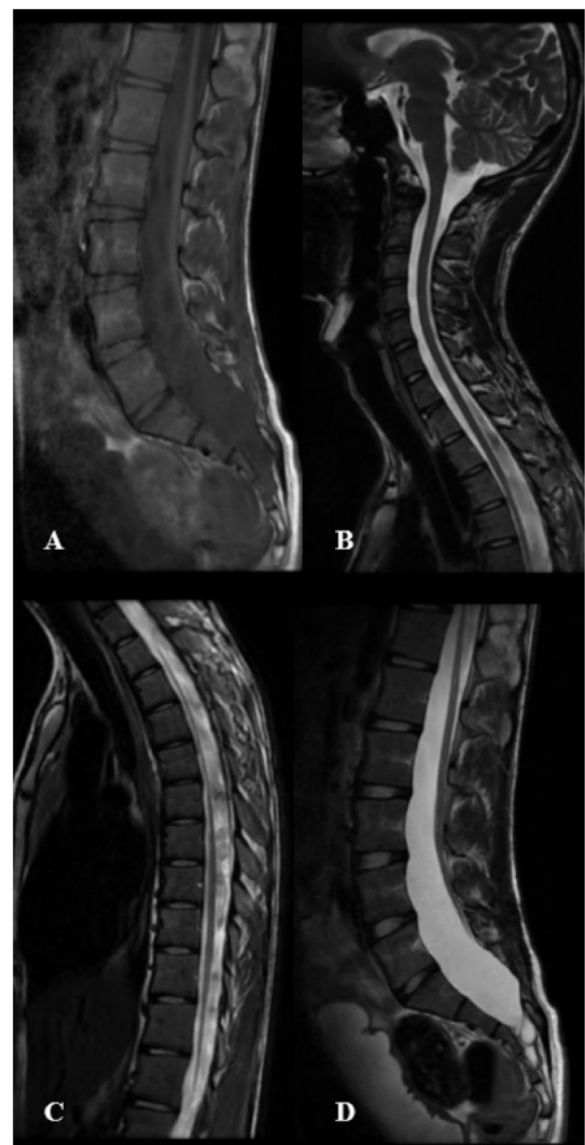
One year follow-up MRI examinations showed complete resolution of the syrinx. A lumbar sagittal T1 image; B cervical sagittal T2 image; C thoracic sagittal T2 image; D lumbar sagittal T2 image
